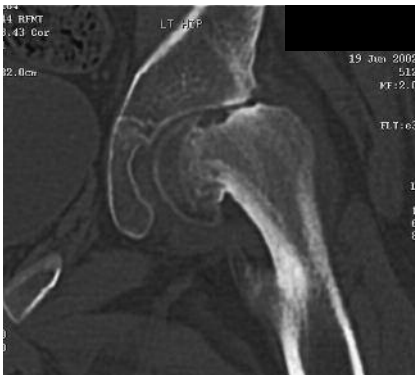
MRI of the left hip showed impingement of the femoral neck on the acetabulum.
